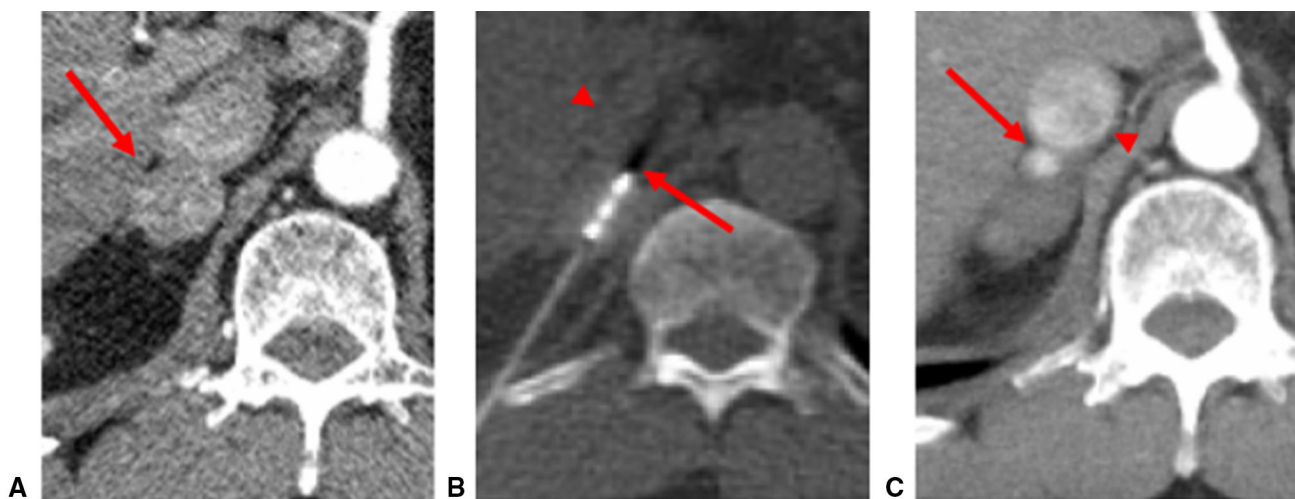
Representative case of tumor recurrence. A Arterial phase CT image demonstrates a hyperenhancing 3.3 cm right adrenal hepatocellular carcinoma metastasis (arrow). B Intraprocedural non-contrast CT image showing the microwave antenna within the tumor but positioned short of deep border of the tumor adjacent to the IVC
